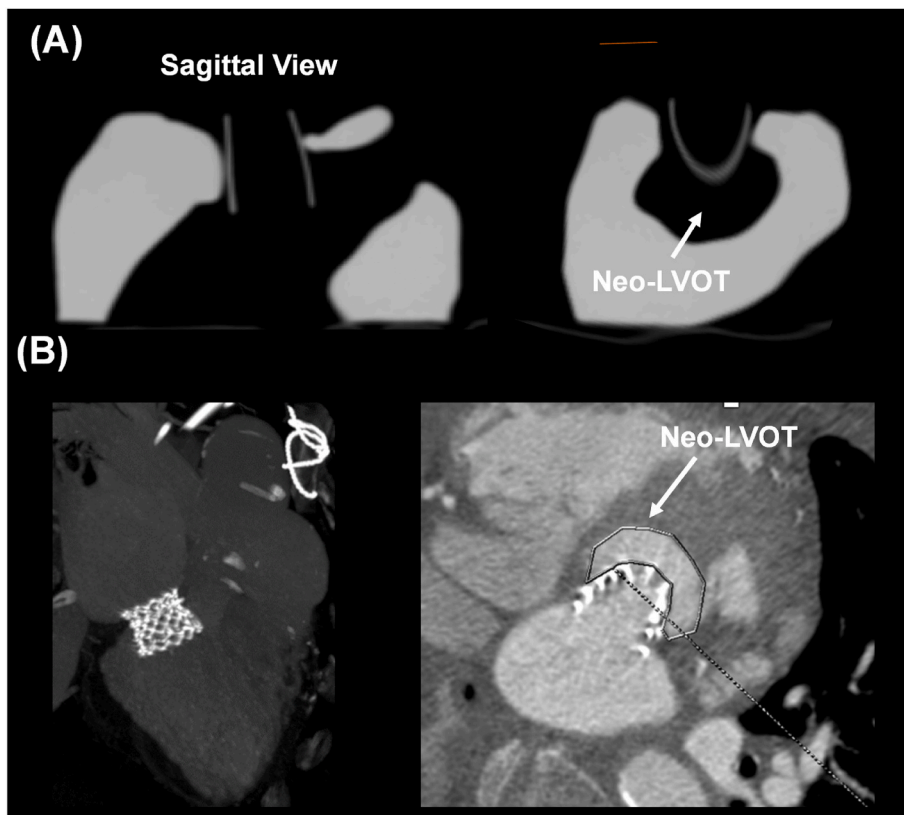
(A) 3D printed models and related CT imaging of the left heart for the patient with ViR; (B) post-TMVR CT images for the same patient.
